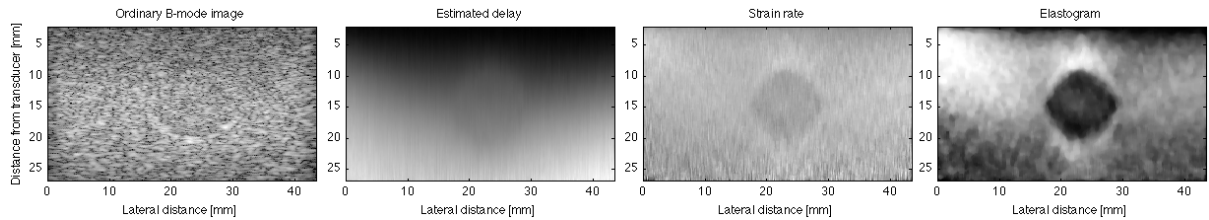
Ordinary B-mode image, estimated time delay values, strain rate values, and elastogram made with a 7.5 MHz Ultrasonix probe, a frame rate of 27 Hz and a demodulation frequency  $f_d = 5$  MHz. Time delay values were estimated by a linear model of  $\hat{\tau}$  within a window size of 4.1 mm
